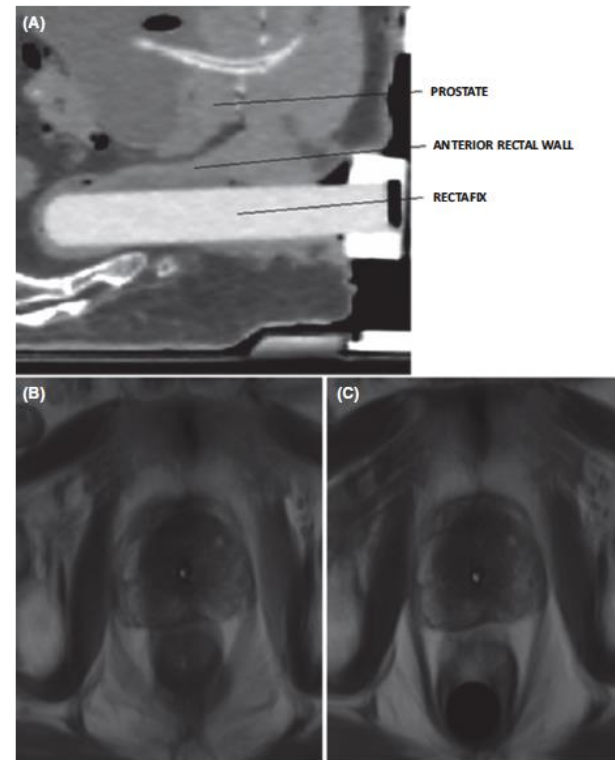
(A) Sagittal CT image of Rectafix RDD in situ with relevant structures identified, (B) MRI images of patient without Rectafix in situ and (C) with Rectafix in situ. Note the posterior displacement of the rectum.
